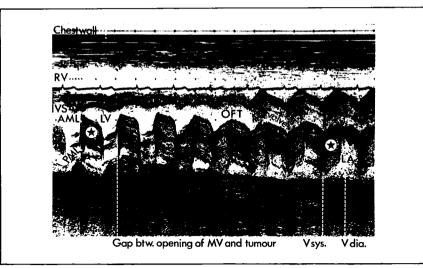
Echocardiographic scan performed on Case 1 demonstrating the prolapsing left atrial myxoma with the mass of reflecting tumour passing between the left atrium and left ventricle.
